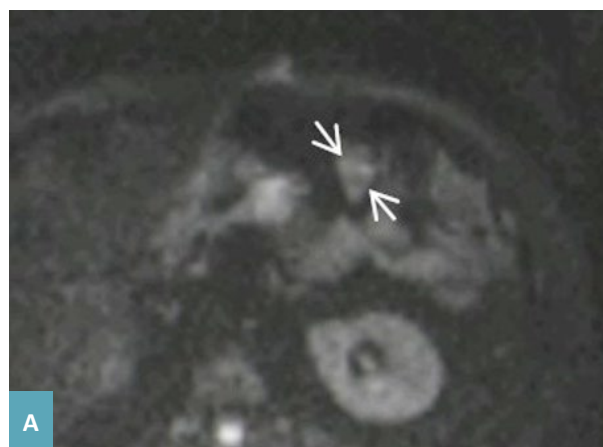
Abdominal MRI dated 10/31/2017. Condition after electroporation. Proximal to the electroporation zone in the isthmus of the pancreas, a volumetric mass of up to 14 mm became apparent that is suspicious of local recurrence or continued growth, which is most clearly visualized with diffuse-weighted imaging (fig. 1A) and in the T2 mode (fig. 1B) – white arrows.
